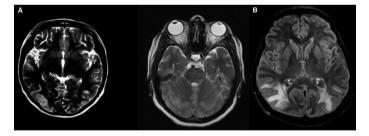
An MRI of the brain. A) Case 1. B) Case 2.
